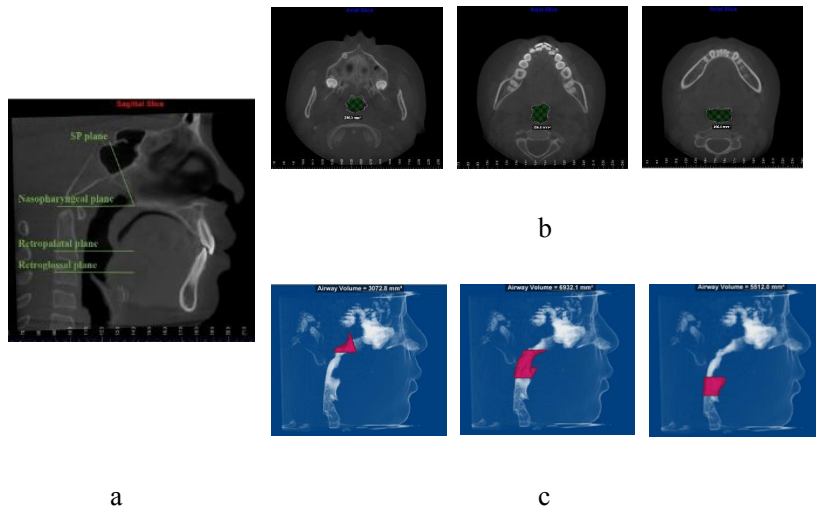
Morphological assessments of UA on CBCT images (a)The nasopharyngeal, retropalatal, and retroglottal upper airway was defined by four planes: the SP plane connects the midpoint of sella turcica and the posterior nasal spine, the nasopharyngeal, retropalatal, and retroglottal plane parallel to the horizontal plane passing through the point of posterior nasal, the tip of uvula, and the tip of the epiglottis respectively,(b) the cross-sectional areas, and (c) volumes were calculated for each region.
